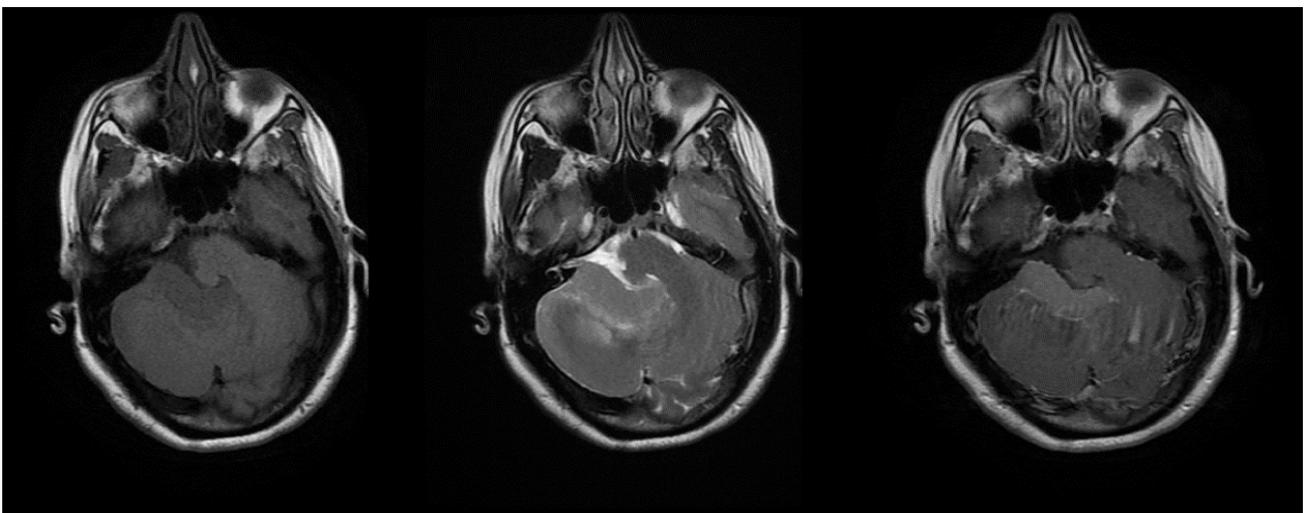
T1, T2-weighted and T1-weighted contrasted images from the pre-operative MRI of a patient
